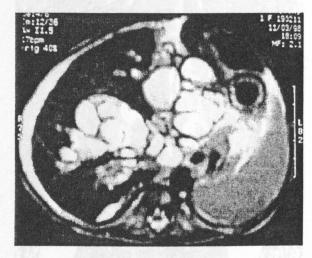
T2-weighted MR image showing multiple cysts connecting with the biliary system in both lobes of the liver with ascites. The outer contour of the liver is irregular.
